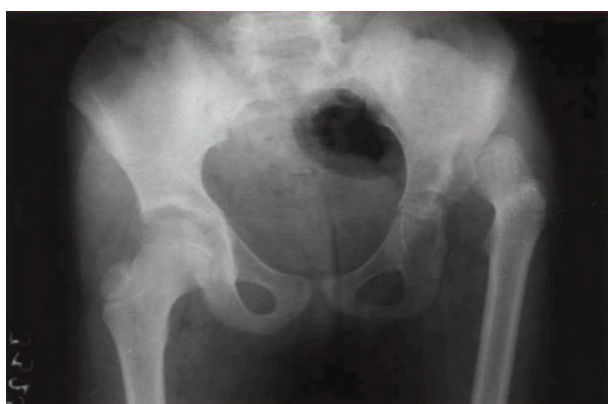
A. Preoperative anteroposterior pelvis X-ray of a 6 years old patient, B. Extraarticular grafting acetabuloplasty was applied and concentric reduction was achieved.
